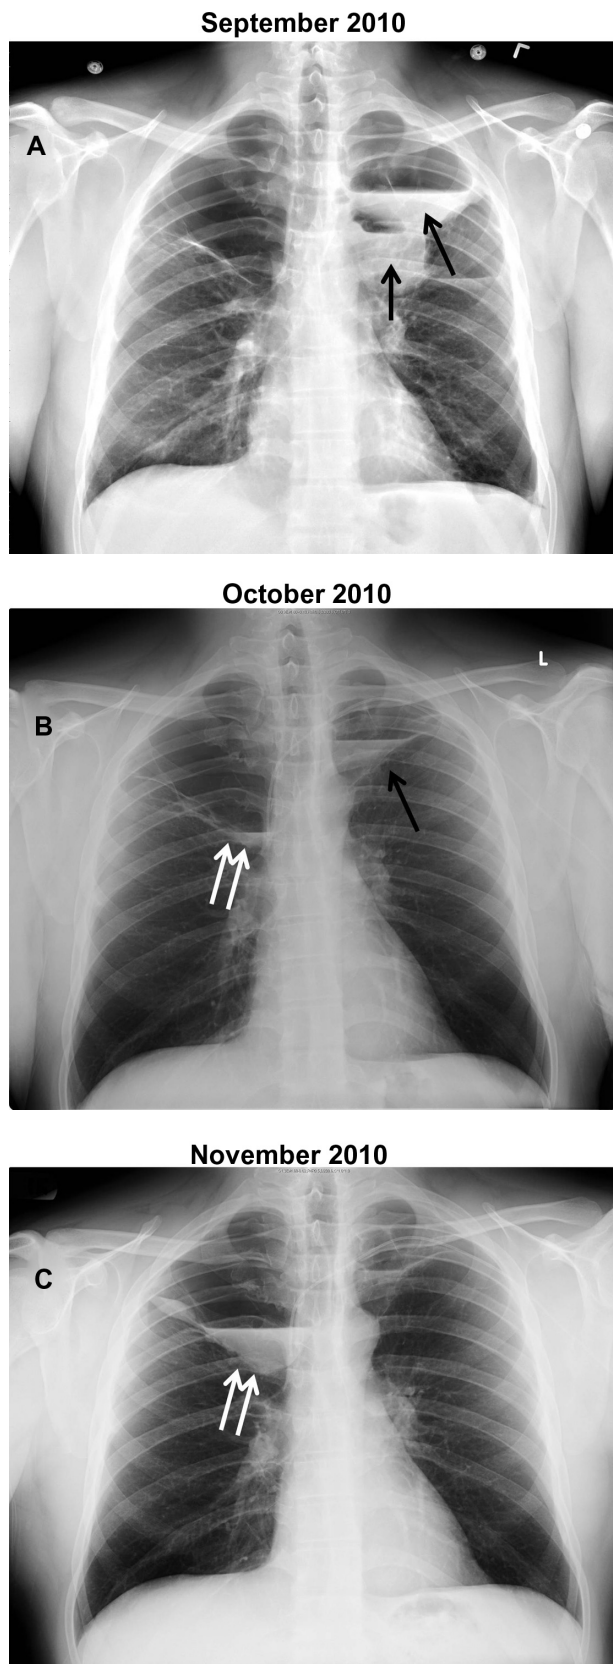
Serial chest radiographs showing (A) air fluid levels in left upper lobe bullae (black arrows). Over the course of 3 months the left upper lobe bullae air fluid level decreases with concurrent development of new air fluid level with in right apical bullae (double white arrow) (B and C).
